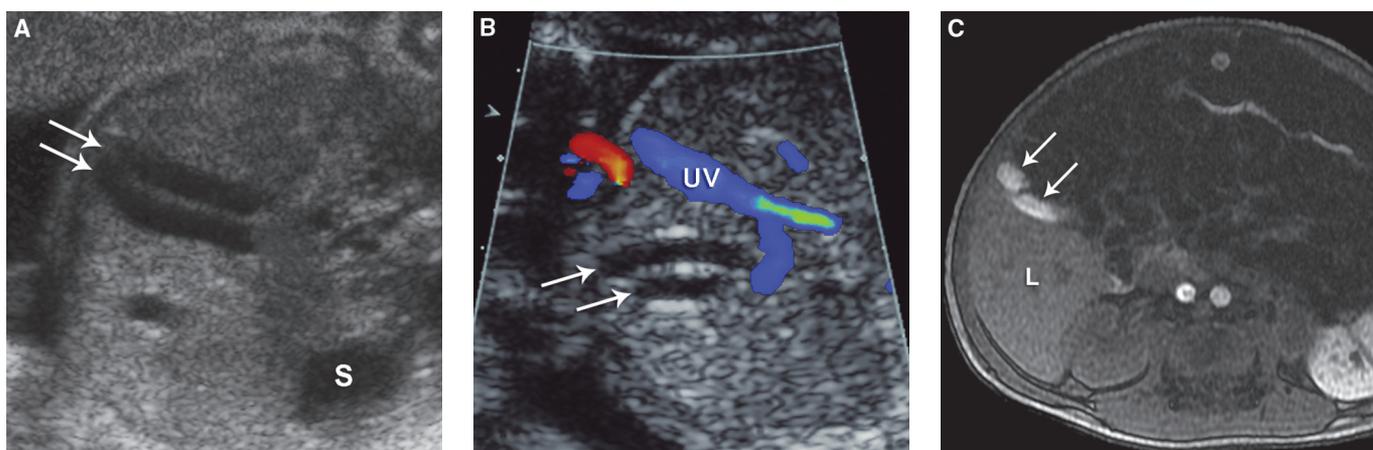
Gallbladder duplication at 30 weeks' gestation. A: Transverse US demonstrates two parallel elongated anechoic structures (arrows) in the gallbladder fossa. S, stomach. B: Color Doppler US demonstrates that the cystic structures (arrows) are to the right of the umbilical vein (UV) and lack internal flow. C: Postnatal MRI demonstrates hyperintense signal of bile in the parallel structures (arrows) in the gallbladder fossa of the liver (L). (Reprinted from Gerscovich EO, Towner D, Sanchez T, et al. Fetal gallbladder duplication. *J Ultrasound Med.* 2011;30:1310–1312, with permission from American Institute of Ultrasound in Medicine.)
